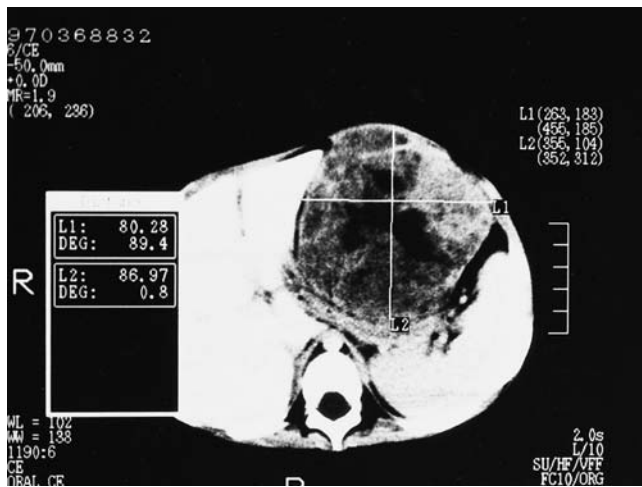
Computerized tomography (CT) scan of abdomen shows a large, heterogeneous mass, 80 × 85mm in diameter, located between liver, spleen, and abdominal wall
